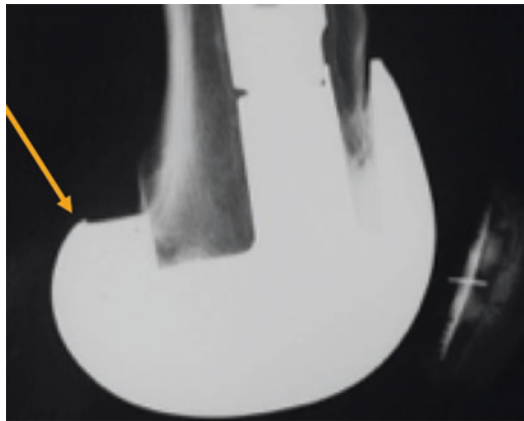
Radiograph of a posterior augment the femoral component
